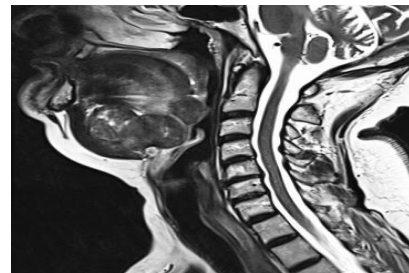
A-C. MRI demonstrating a thyroglossal duct cyst.
